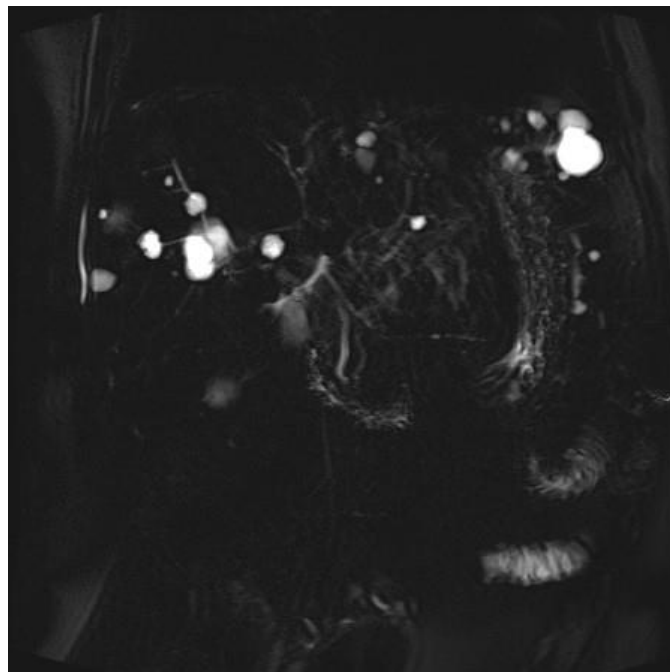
Liver MRI in BILI-MRI sequences demonstrating cyst communication with the intrahepatic biliary ducts (IHBD)
